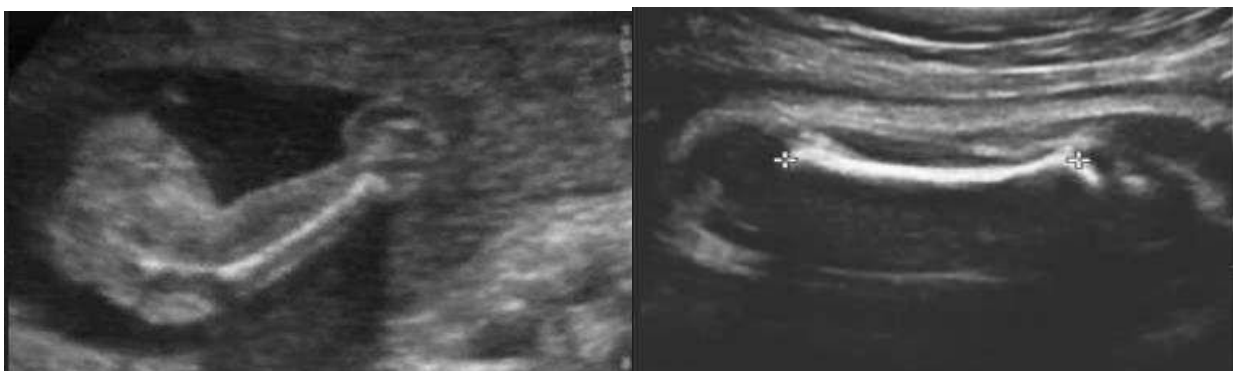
Obstetric ultrasound image showing femoral hypoplasia–unusual facies syndrome in the fetus. Paladini, D. Maruotti et al (2007)
